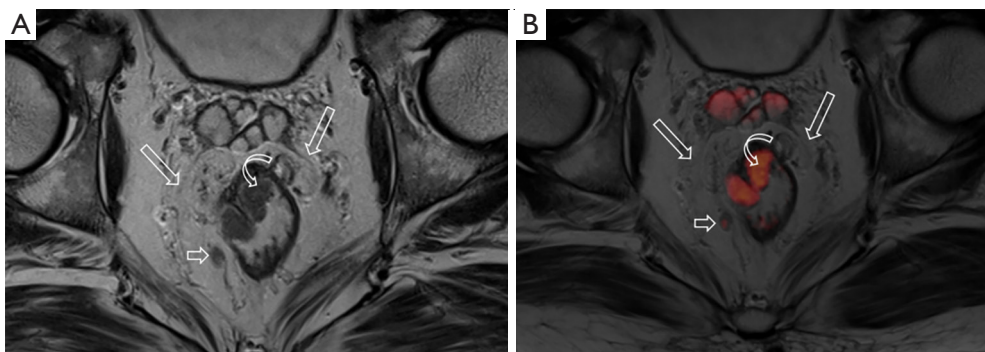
A 59-year-old man with low RC. (A) Axial MR rectography shows the tumor (curve arrow), enlarged lymph nodes (short arrows) and clear mesenteric fascia (long arrows); (B) fused axial MR rectography and DWI visualizes the tumor (curve arrow) and enlarged lymph nodes (short arrows) with restricted diffusion in color. The clear mesenteric fascia (long arrows) can be also identified. RC, rectal cancer; DWI, diffusion weighted imaging.
